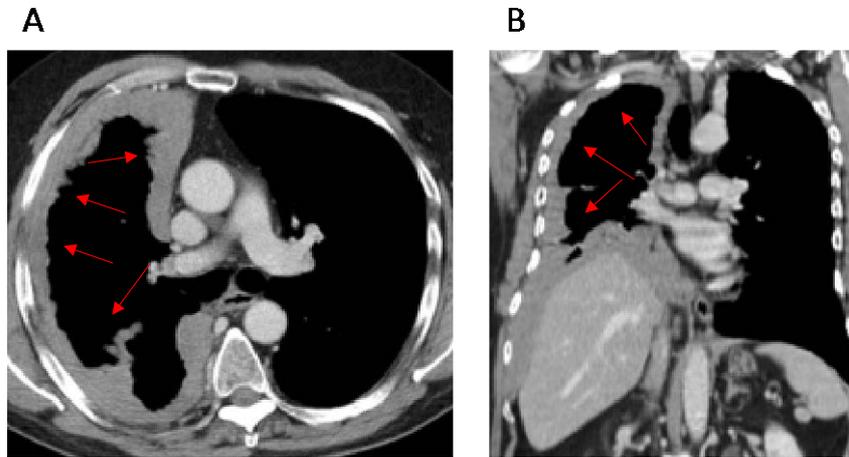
(A) Axial and (B) coronal reformat CT of a 52-year-old man with malignant mesothelioma of the right hemithorax (red arrows).
